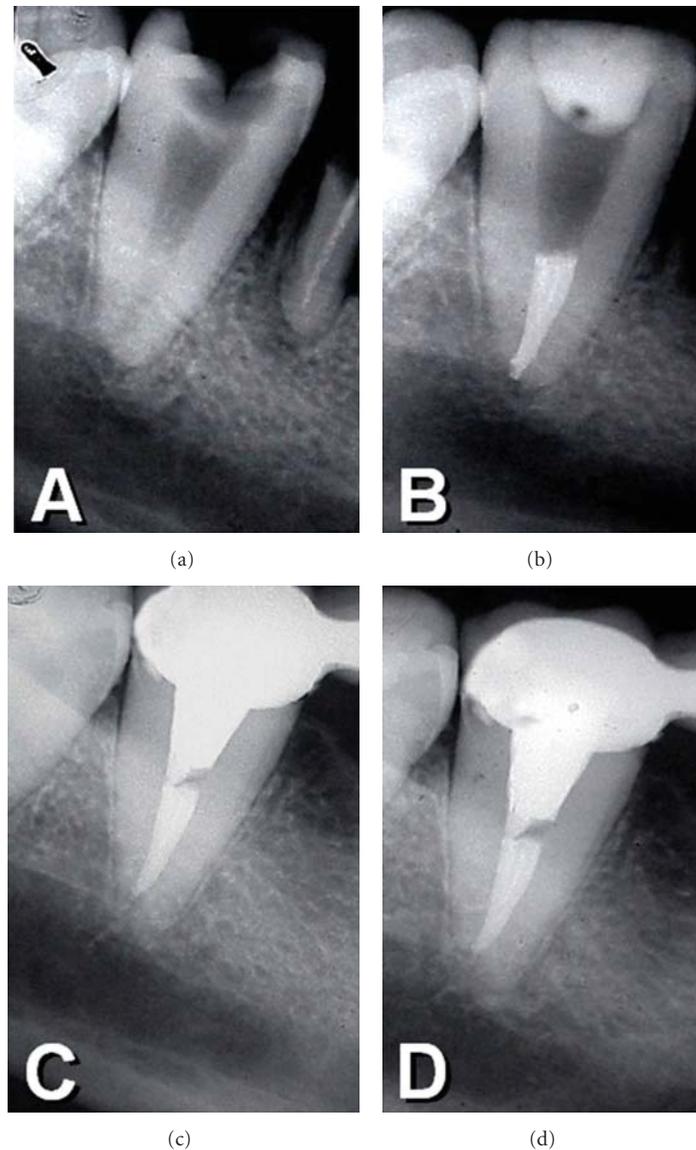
(a) Preoperative radiograph of a mandibular right second molar with deep caries lesion. (b) Immediate postoperative radiograph. Note the root canal filling was partially removed in order to accommodate a post. (c) and (d) 8- and 10-year recall radiographs showing normal periapical tissues.
